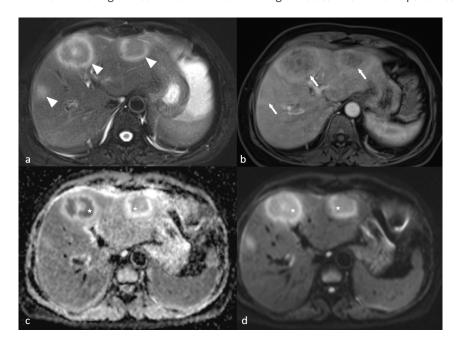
The initial magnetic resonance imaging demonstrates A) multiple hepatic lesions characterized by central hypointensity and a peripheral halo of hyperintensity (arrowheads) on T2-weighted sequences. B) On contrastenhanced T1-weighted sequences with fat saturation, the lesions exhibit predominant peripheral enhancement (arrows). C, D) Diffusion-weighted imaging shows a low apparent diffusion coefficient within the lesions, without clear diffusion restriction (asterisk).
